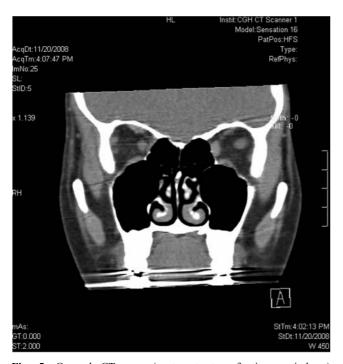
Coronal CT scan (post-contrast, soft tissue windows) showing thickening of the left medial and inferior recti.
